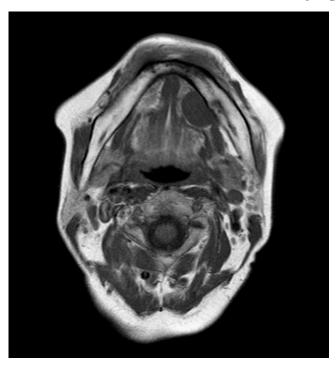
T1-weighted axial magnetic resonance imaging shows a well-defined ovoid mass in contact with the left submandibular gland.
